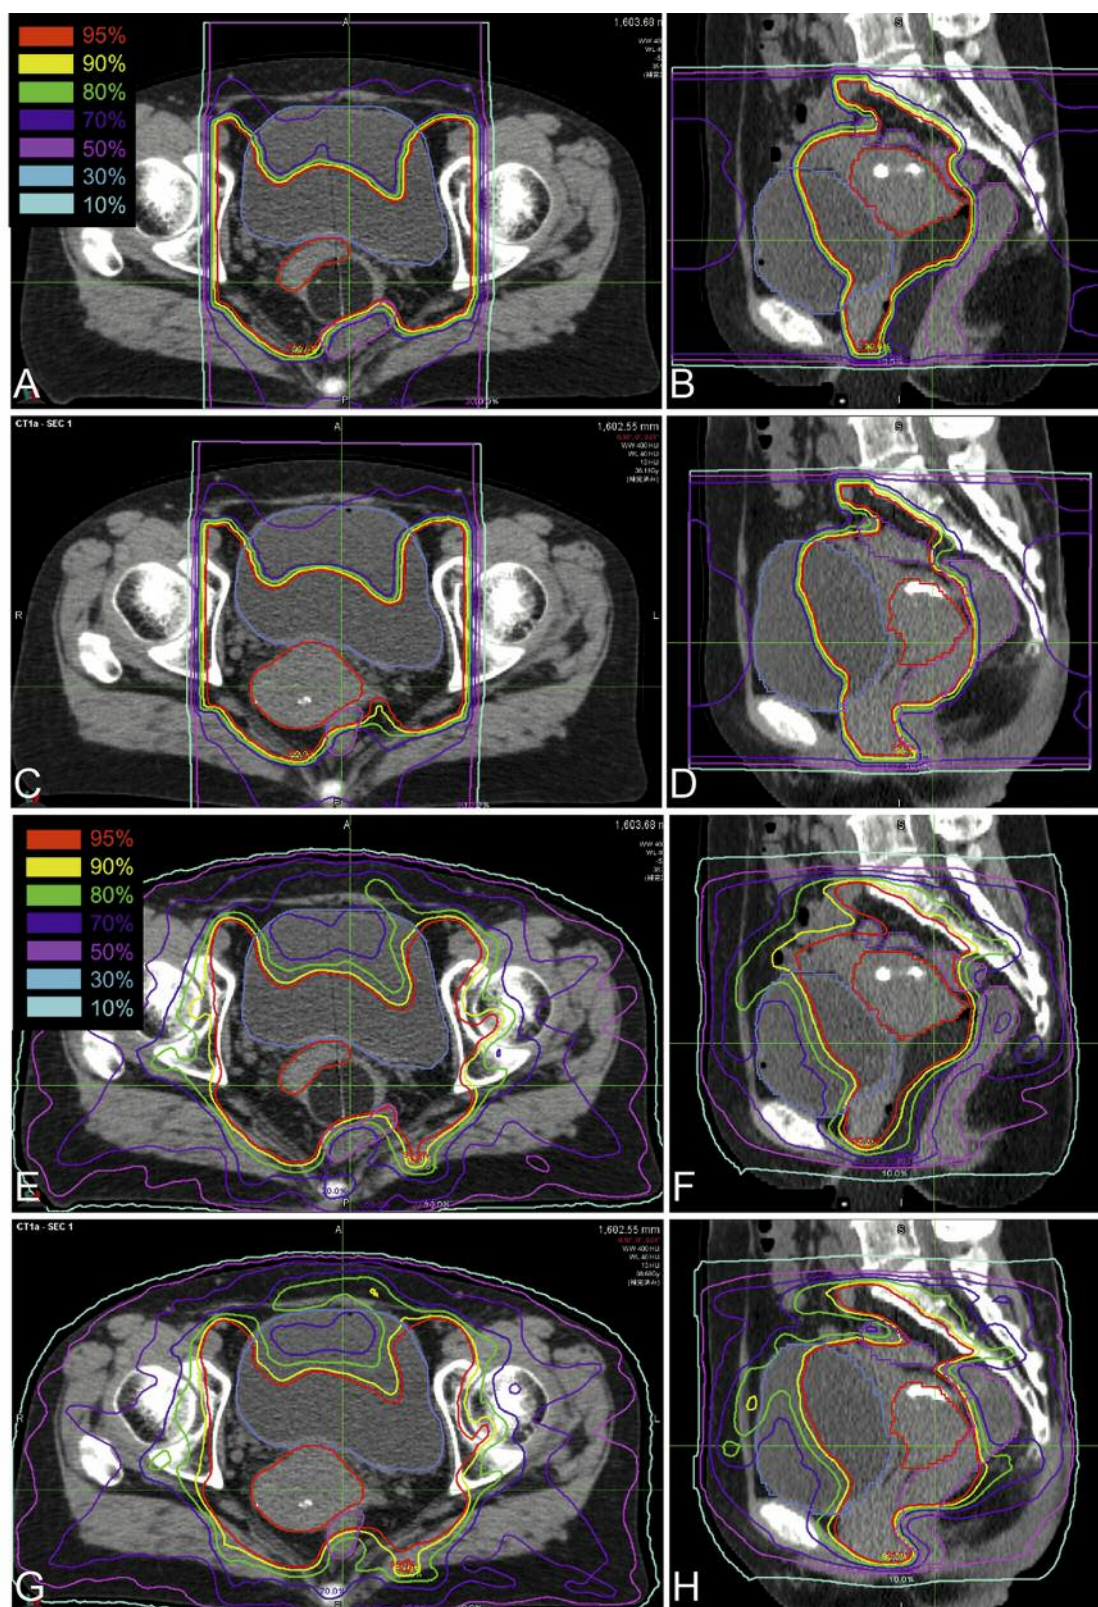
Computed tomographic image and dose distribution of carbon-ion radiotherapy (A-D) and intensity-modulated radiation therapy (E-H). Cases with (A, B, E and F) and without (C, D, G and H) the device in axial (A, C, E and G) and sagittal (B, D, F and H) planes. The red, magenta, purple, and blue contours delineate the cervical tumour, rectum, sigmoidal colon, and bladder, respectively.
